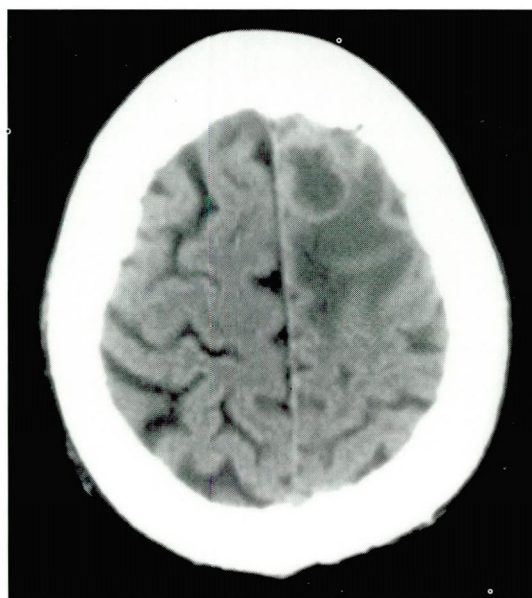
MRI (left) and CT (right) of a typical patient with brain metastases.
